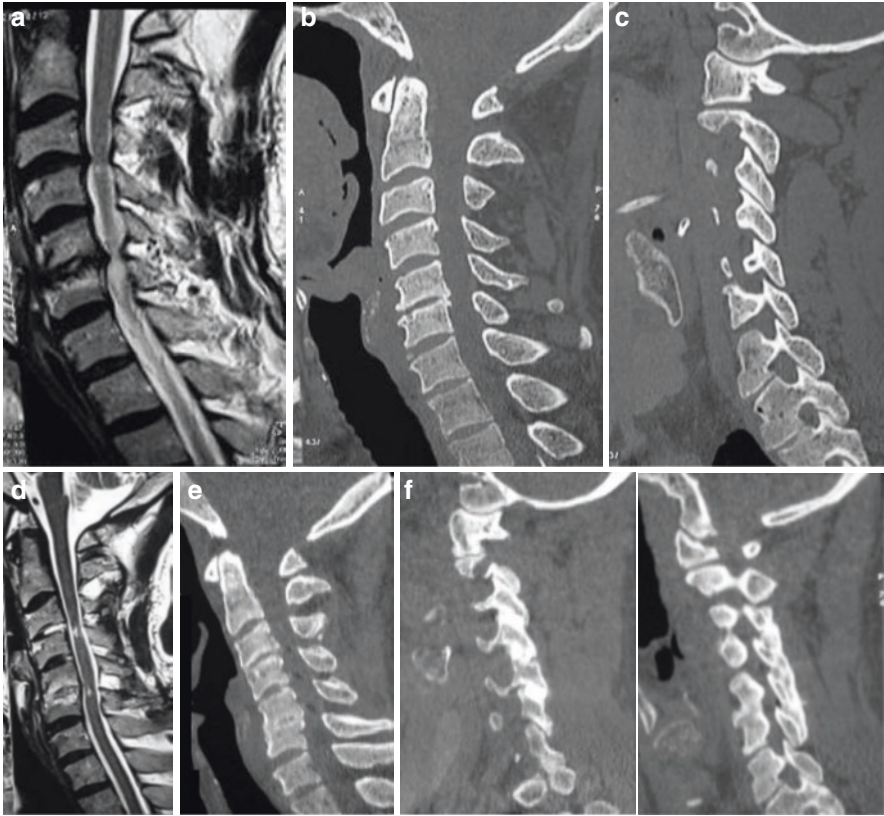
Images of a 48-year-old male patient showing fixation using facet spacers. (a) T2-weighted MRI showing evidence of significant spondylotic disease with cord compression opposite C3–4 and 5–6 disc spaces. (b) CT scan showing degenerative changes in the spine. (c) Sagittal section depicting the facets. (d) Postoperative MRI showing reduction in the extent of cord compression. Resorption of the osteophytes and reduction in the buckling of posterior longitudinal ligament and ligamentum flavum at the levels treated can be seen. (e) CT scan showing distraction and increase in the intervertebral and interspinous process spaces. (f) Sagittal section through the facets showing the spacers with the C3–4, 4–5, and 5–6 facet joints with evidence of arthrodesis
